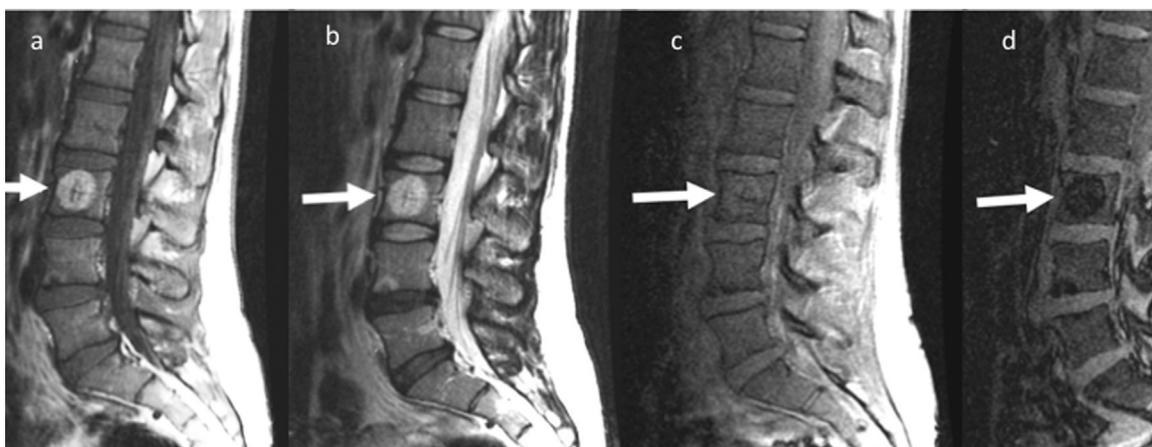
a–d: 1a – Sagittal T1-weighted spin echo (SE); TR: 500 ms, TE: 9 ms. 1b – T2-weighted fast spin echo (FSE); TR: 4600 ms, TE: 88 ms. 1c – In-phase gradient-recalled echo (GRE); TR: 125 ms, TE: 4.6 ms, flip angle: 90°. 1d – coronal opposed-phase gradient-recalled echo (GRE); TR: 125 ms; TE: 2.3 ms, flip angle: 90°.
